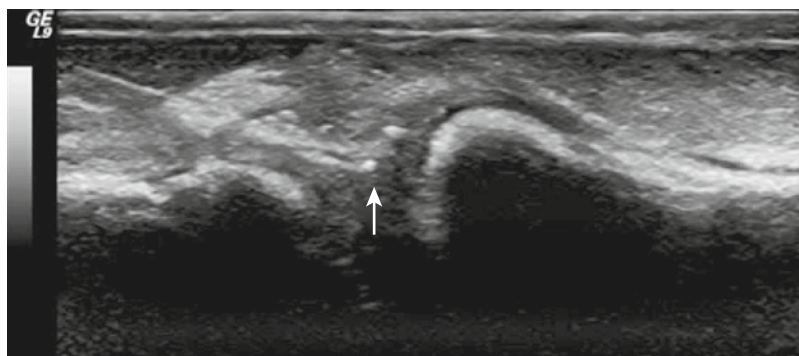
Ultrasound-guided intervention is demonstrated. For an intra-articular injection, the shaft and tip of the needle are visible, with the tip located within the joint space (*arrow*). The needle is parallel to the long axis of the transducer.
